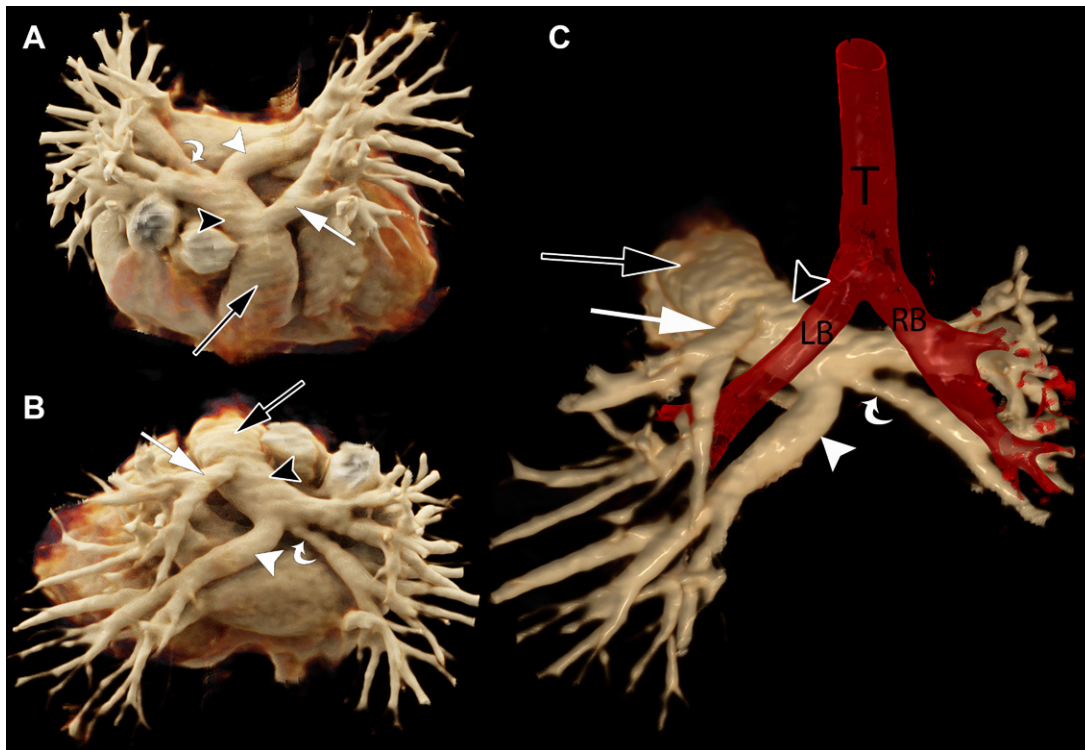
(A, B) Contrast-enhanced CT angiographic chest three-dimensional volume-rendered images obtained using cinematic rendering in the (A) anterosuperior and (B) posterosuperior views. The main pulmonary artery trunk (black arrow) bifurcation gives rise to the left upper lobe pulmonary artery (white arrow) and right pulmonary artery (RPA) (black arrowhead). The stenotic lower RPA is again demonstrated (curved white arrow). The partial anomalous left pulmonary artery (PALPA) (white arrowhead) is seen arising from the RPA. (C) Three-dimensional volume-rendered image of the pulmonary arteries with superimposed airways demonstrates the PALPA coursing posterior to the left mainstem bronchus (LB). RB = right mainstem bronchus, T = trachea.
